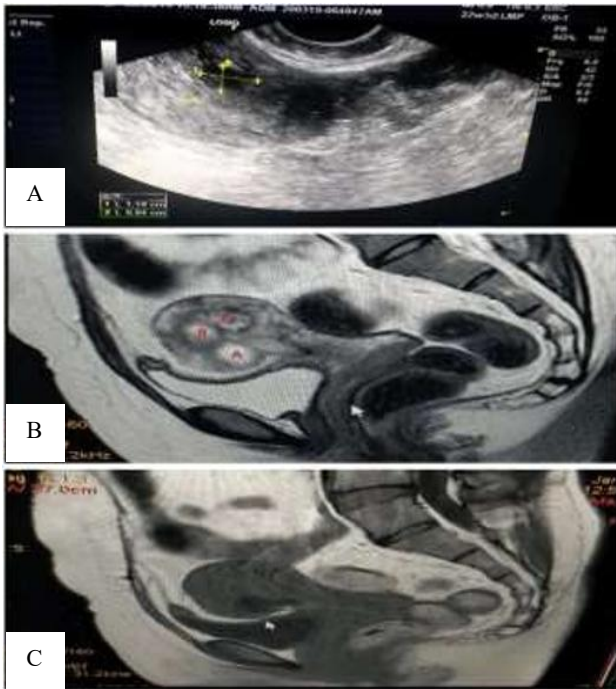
(A) showing ultrasound findings, (B) the myometrium in the anterior uterine wall which corresponded to the lower uterine segment was noted to be thinned out and measured 3 mm in maximum thickness and (C) sagittal T2-weighted MRI image showing a caesarean scar ectopic pregnancy (CSEP).
